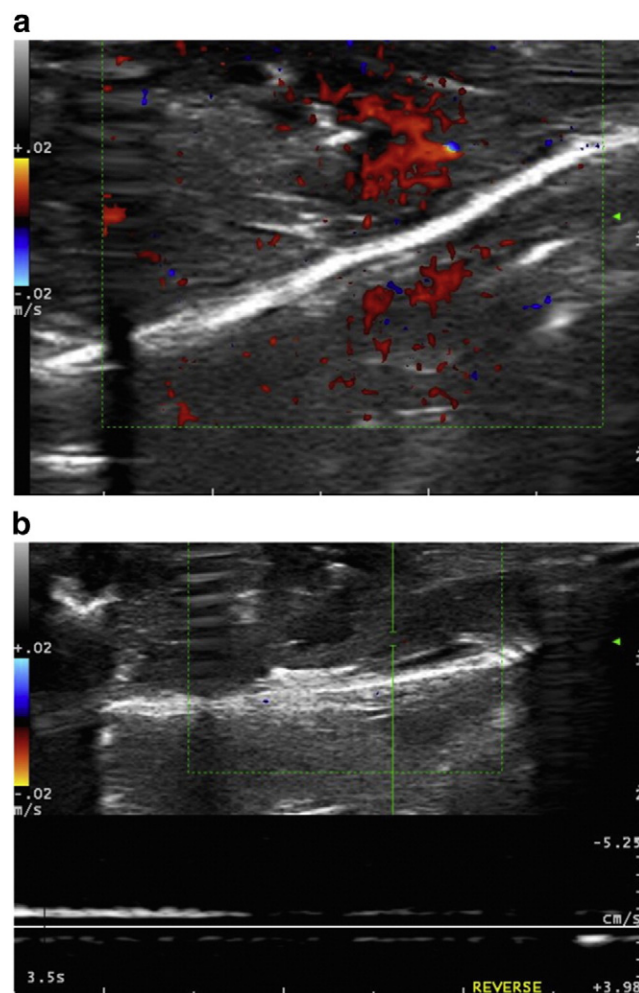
a Non-torsed ovaries with Color Doppler. b Torsed ovaries with Color Doppler.
